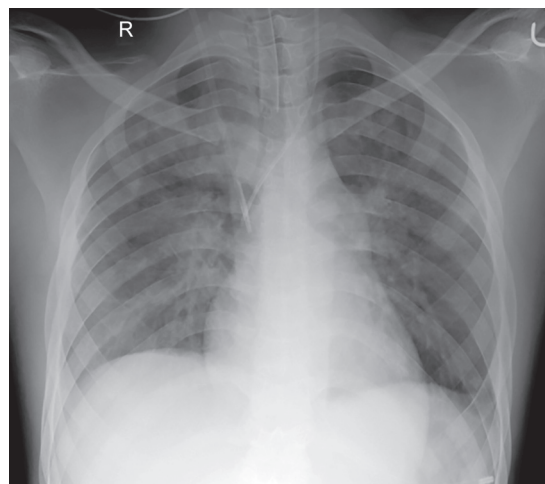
Thorax radiograph after intubation and placement of right and left central venous catheter
